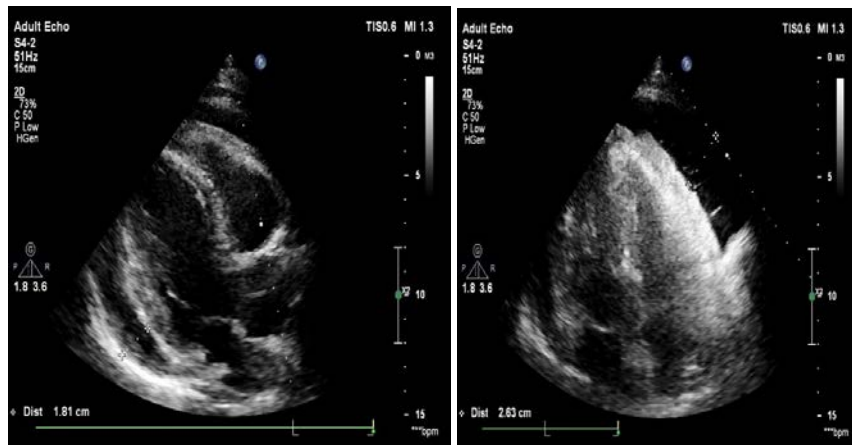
Transthoracic echocardiography (TTE).
